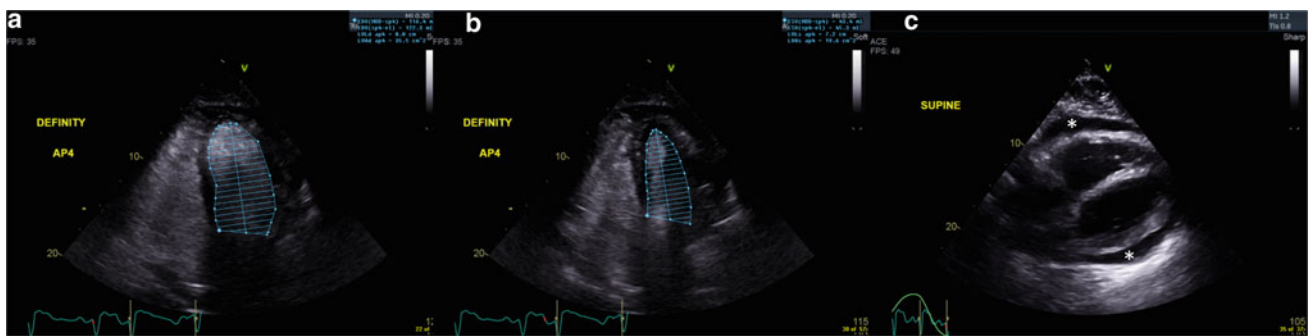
Echocardiographic images showing normal left ventricular ejection fraction, 55% per biplane modified Simpson's, and a moderate-sized pericardial effusion. a Apical four-chamber view with micro-bubble-enhanced image showing modified Simpson's
